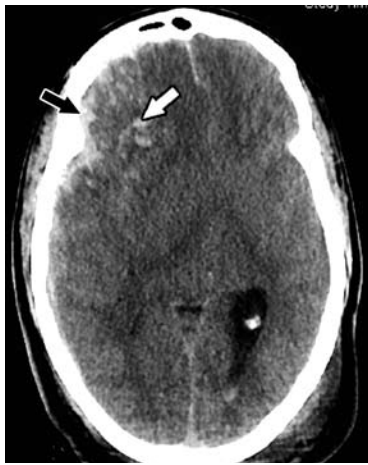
A brain CT (plain) of a traumatic brain injury patient showing a right frontal acute subdural hematoma (black arrow), multiple petechial hemorrhages in the right frontal lobe (white arrow) with swelling of the right hemisphere and mass effect.
